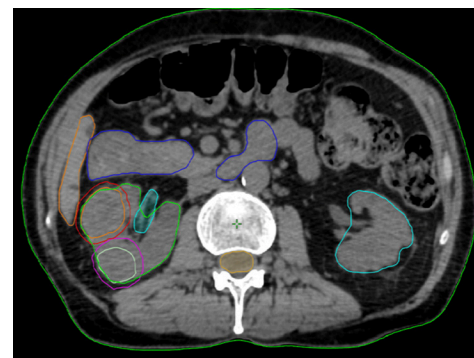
Delineation of the GTVs and OARs on the planning CT scan
